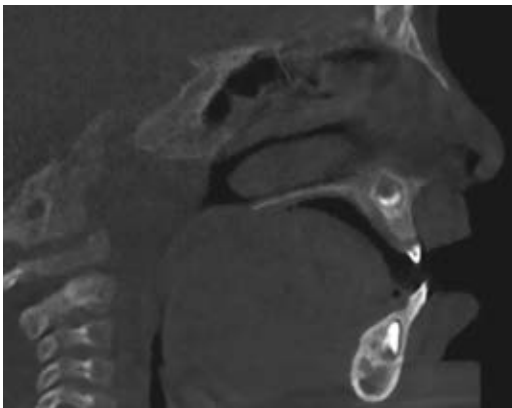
Computed tomography showing the airway obstruction due to the posterior lingual position.
